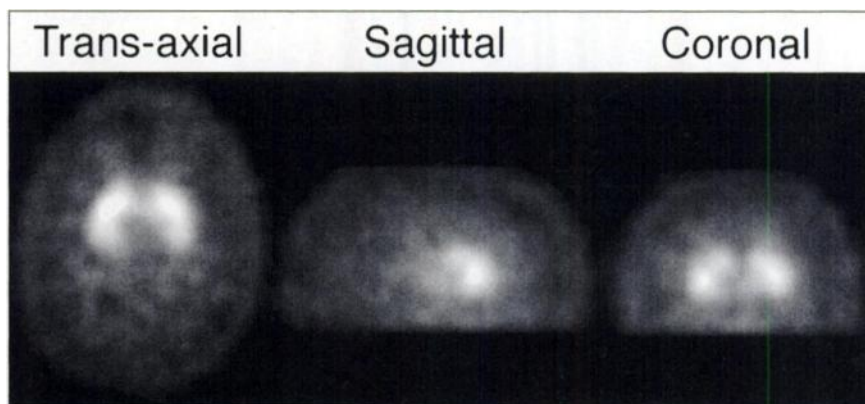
Transaxial, sagittal, and coronal SPECT images of brain of healthy volunteer 30-45 min after injection of 370 MBq ^{123}I IACFT.
